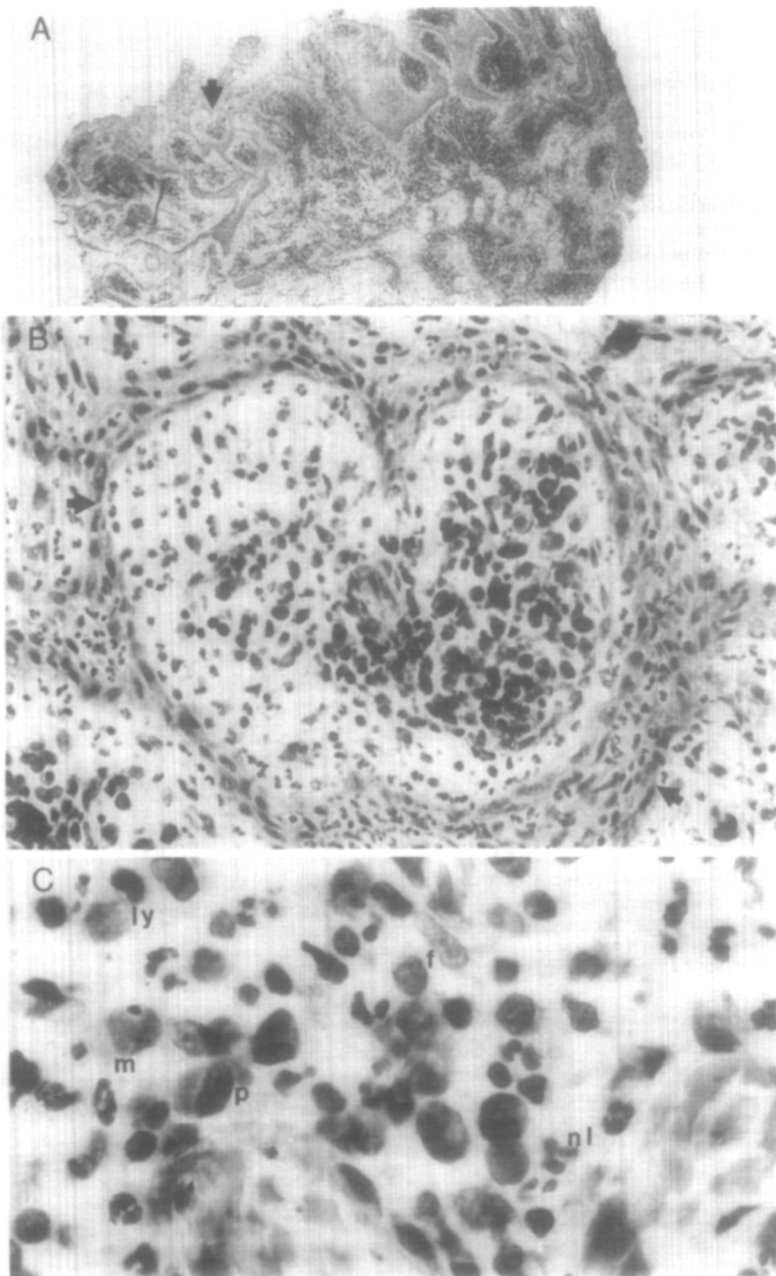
Case 214, Tooth No. 2 had a history of root canal therapy 16 years earlier. Currently there was a generalized periodontal disease with acute pain in the region of this tooth. There was a 1 mm. area of apical rarefaction on the mesial root. A hemisection was performed and the mesial root was removed. A 2-year follow-up indicated an asymptomatic tooth with uncertain radiographic status (Fig. 10). *A*, Granuloma with epithelium, but no sacs with liquefied or semisolid tissue, *B*, From area indicated by arrow in *A*. Epithelium enclosing loose connective tissue with acute and chronic inflammatory cells. Neutrophilic leukocytes also among epithelial cells. *C*, From concentration of cells in *B*. Neutrophilic leukocytes (*nl*), lymphocytes (*ly*), macrophage (*m*) with inclusion in lacuna, plasma cell (*p*) with two nuclei. (Original magnifications: *A*, $\times 25$; *B*, $\times 320$; *C*, $\times 1,000$.)
